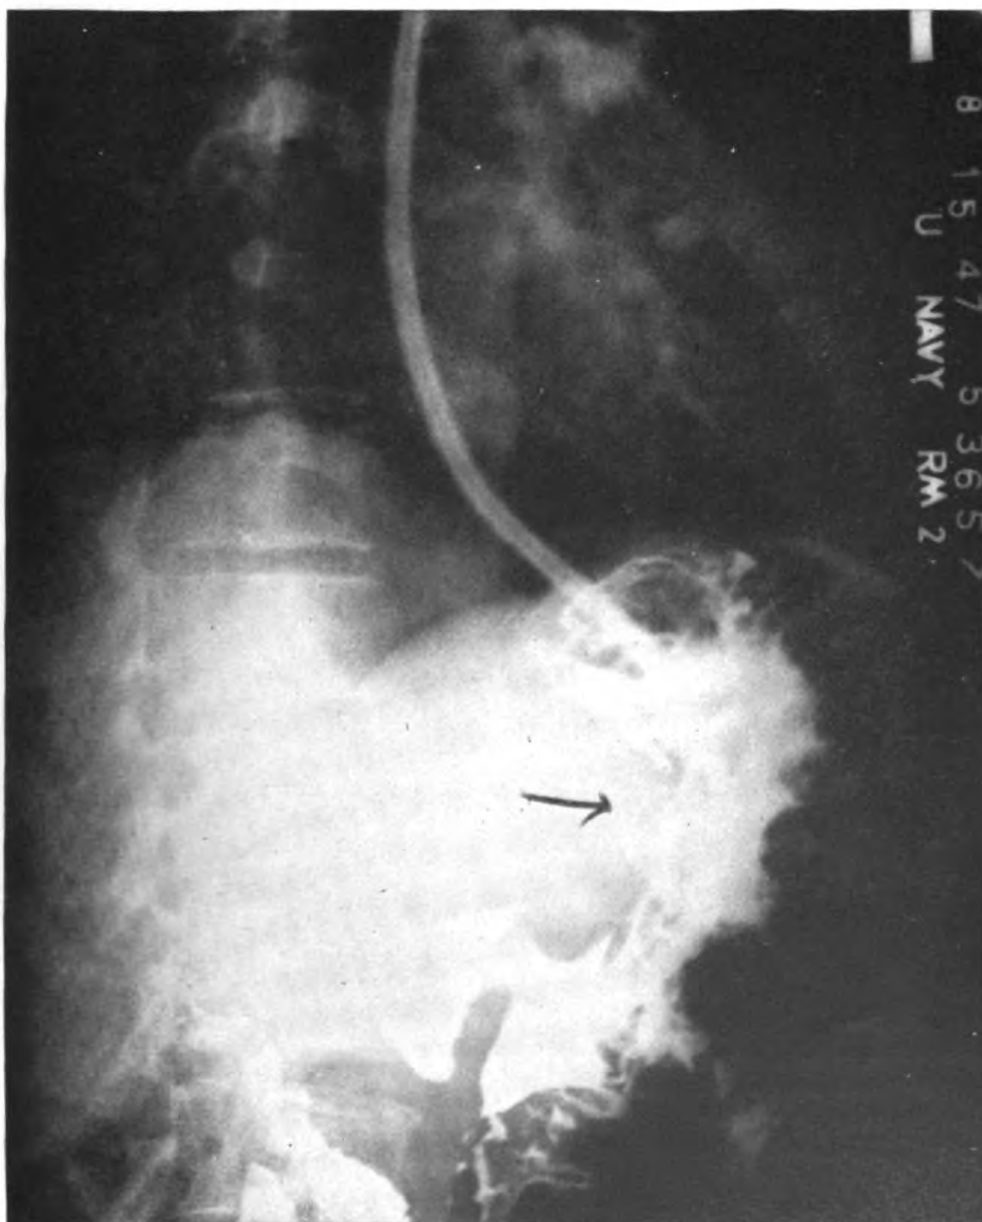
Roentgenogram taken a few days post-operatively shows the large ulcer with arrow pointing out the deepest part of the crater.
